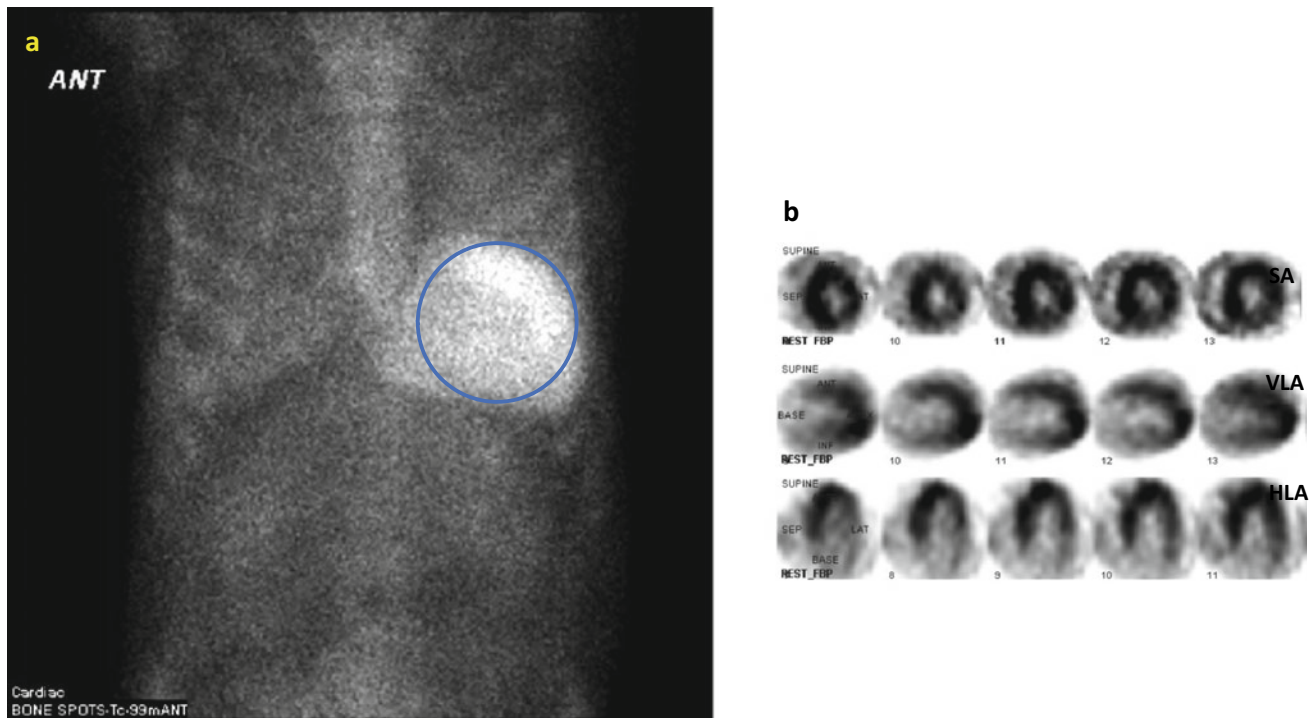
a Technetium-99 m pyrophosphate (Tc-99 m PYP) scintigraphy at 1 h after radiotracer injection showing myocardial PYP uptake, with a semiquantitative or visual grade of 3 and heart-to-contralateral lung (H/CL) ratio of 1.6. b SPECT confirms myocardial radiotracer uptake. SA, short axis; VLA, vertical long axis; HLA, horizontal long axis
